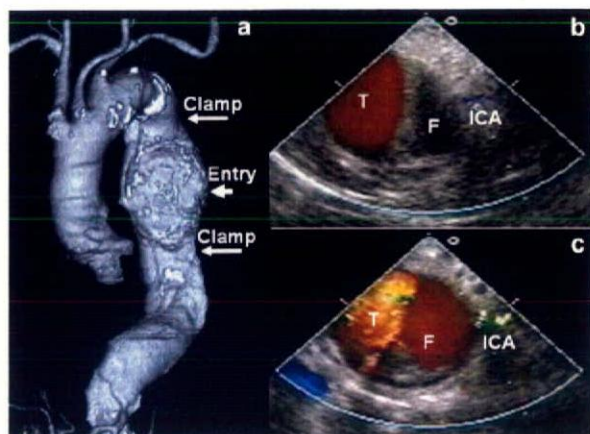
A three-dimensional computed tomography image (a). The aortic dissection extends from the distal arch to just proximal to the superior mesenteric artery. The primary tear is located at the mid descending aorta. The mid descending aorta exhibits an aneurysmal change, and its maximum diameter is 61 mm. The false lumen is not completely thrombosed. Arrows indicate the segmental aortic clamping and the entry sites. A transesophageal echocardiography image (b, c). It shows blood flow congestion in the false lumen and decreased flow in the intercostal arteries originating from the false lumen during segmental aortic clamping (b). After releasing the segmental clamps, the blood flow in the false lumen and intercostal arteries recovered (c). T; true lumen, F; false lumen, ICA; intercostal artery.
